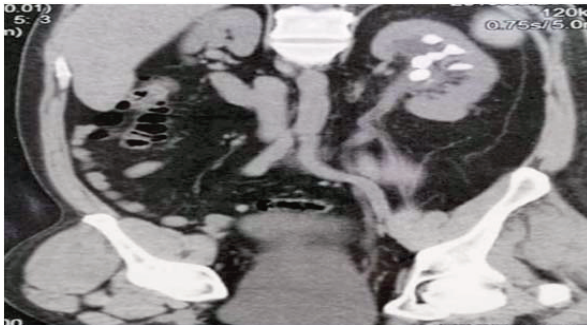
Non-contrast CT abdomen and pelvis showing preoperative left renal stone.
